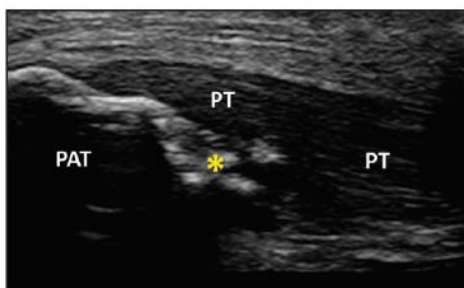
Ultrasound image of chronic patellar tendinopathy. Note the diffusely hypoechoic (darker than normal) patellar tendon (PT) extending from the inferior patellar pole. Intratendinous calcifications (asterisk) are seen at the enthesis, correlated with the patient’s point of maximal tenderness. Left is cephalad, right is caudad, top is superficial/anterior, and bottom is deep/posterior. Abbreviation: PAT, patella.
